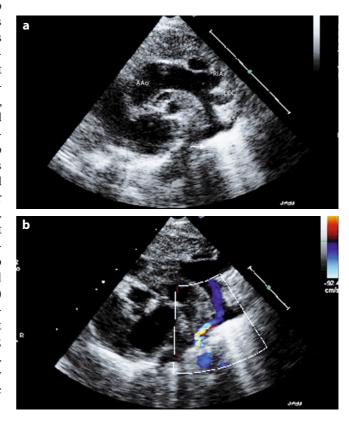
Parasternal long-axis view in systole. a The valve has a domed appearance, with thickening of cusps (*arrow*). *LA* left atrium; *RV* right ventricle; *LV* left ventricle. b Color Doppler demonstrating a turbulent flow across the aortic valve
